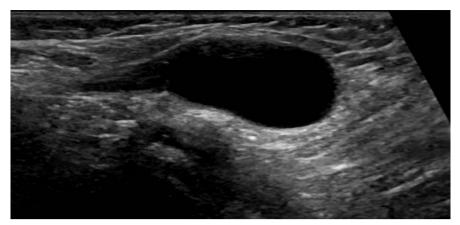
Longitudinal gray-scale superficial ultrasound of the right groin showing an elongated fluid-filled cystic lesion medial to the pubic bone and at the level of the right superficial inguinal ring. No herniation of pelvic organs or bowel loops seen
